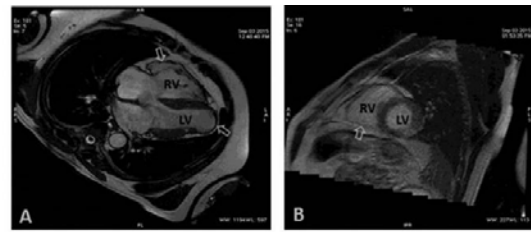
Cardiac magnetic resonance imaging. A-Cine study: Long axis view shows RV dilatation with dyskinesia and LV aneurysm (arrows). B-short axis view after LGE reveals RV wall fibrosis (arrow). LV=left ventricle; RV=right ventricle
